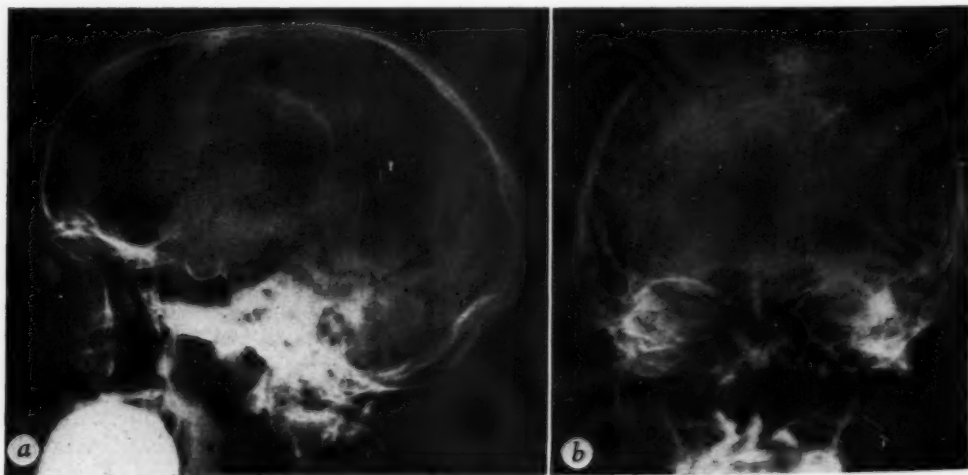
Cholesteatoma. *a*. Lateral roentgenogram revealing irregular shadows of calcification in the peripheral portion of the tumor. The curvilinear arrangement of the calcium shadows suggests that the tumor is cystic in nature. *b*. Postero-anterior roentgenogram revealing calcification within walls of a cholesteatoma and secondary pressure erosion of the inner table of the overlying calvarium.
